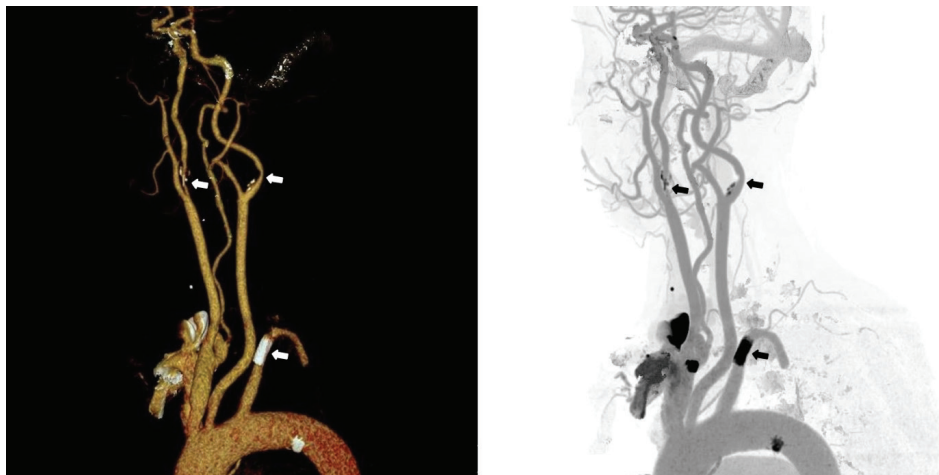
Computed tomography angiography results. Arrows show right and left internal carotid artery stenosis (>50%) and endovascular stent in the left subclavian artery.
